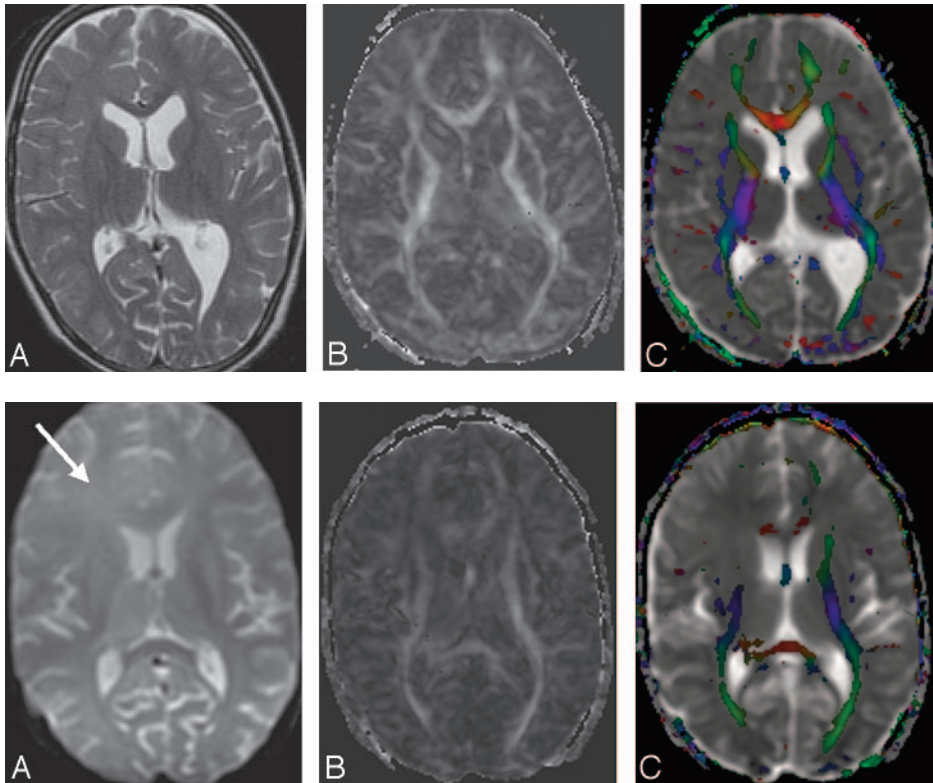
A 12-year-old boy with clinical findings of SSPE shows normal appearance on the T2-weighted image (A). FA map (B) shows bilateral significantly low FA values in the white matter (right frontal white matter, 0.15; left frontal white matter, 0.18; right parietal white matter, 0.16; left parietal white matter, 0.15; right occipital white matter, 0.17; left occipital white matter, 0.12). Color-coded FA fused with the ADC map (C) shows the abnormality more clearly.
